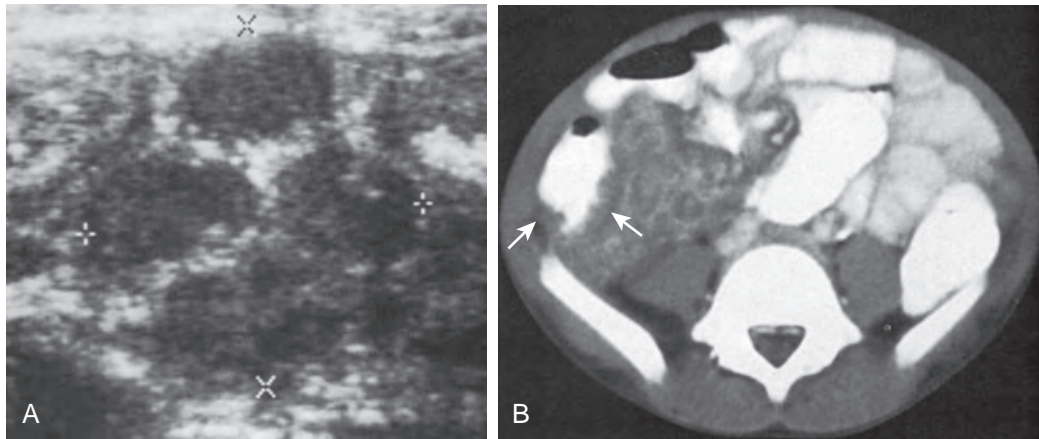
Yersinia enterocolitis*. A. Several enlarged lymph nodes (cursors) are seen on this sagittal sonogram of a child whose appendix appeared normal. B. The enlarged lymph nodes produce an inhomogeneous mass in the right iliac fossa. The wall of the cecum (arrows) is thickened on the CT scan.
